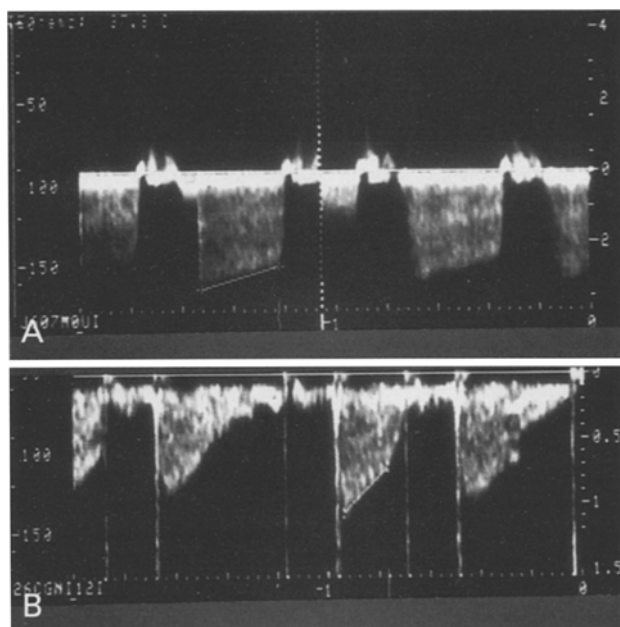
Velocity flow profile of a thrombotic prosthetic mitral valve using a continuous wave Doppler analysis before (A) and after thrombolytic therapy (B)
